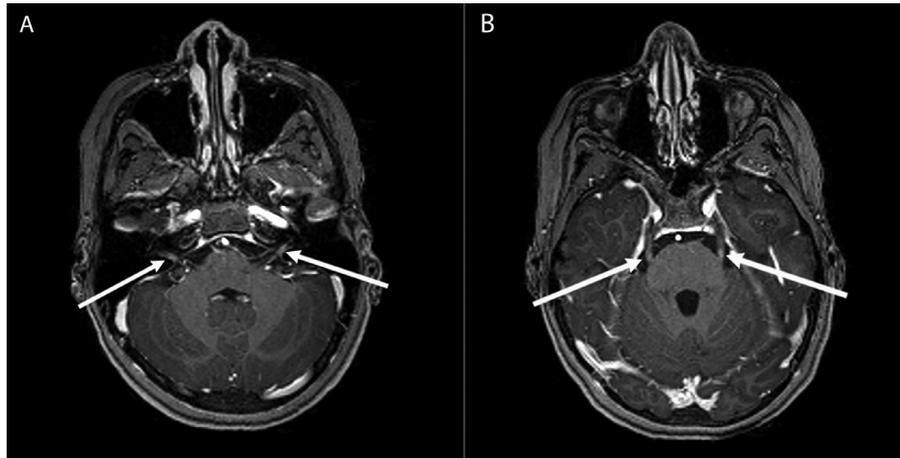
A 11-year-old girl COVID-19 positive 3 days prior presents with tinnitus and cranial neuropathy. This was followed by 4 days of fever, nausea, vomiting, ear pain, and diffuse abdominal pain with initial concern for multisystem inflammatory syndrome in children (MIS-C) –also known as pediatric inflammatory multisystem syndrome (PIMS)—in a patient with known COVID, elevated D-dimer of 936, lipase of 130, and whose course was complicated by ongoing fevers, worsening acute mental status changes. Lumbar puncture and clinical data suggesting possible encephalitis (infectious vs autoimmune). (A) Axial post contrast T1-weighted image shows bilateral IAC nerve root enhancement likely related to cochlear and/or vestibular cochlear nerves (white arrows) consistent with neuritis, likely contributing to tinnitus. (B) Axial post contrast T1-weighted image show bilateral trigeminal nerve, cisternal segment enhancement, consistent with trigeminal neuritis. *Images courtesy of Dr. David D. Pasquale, MD.
